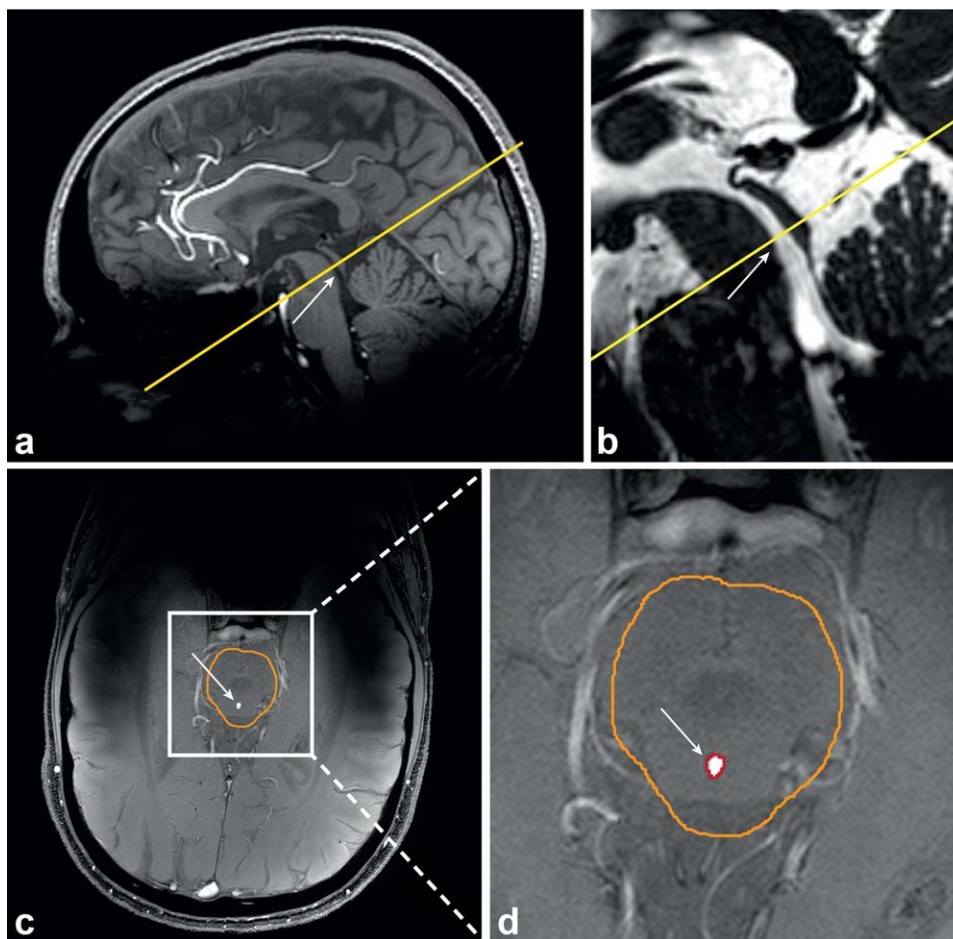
Slice planning of the PC-MRI scan (single slice, yellow) for Volunteer 5, relative to a whole-brain 3D T₁-weighted TFE scan (A) and a whole-brain T₂-weighted 3D balanced gradient echo scan (B), the corresponding, manually drawn, brain stem ROI (orange) in the magnitude image (C), and the automatically determined aqueduct ROI (red) (D). The cerebral aqueduct is indicated by the white arrow.
